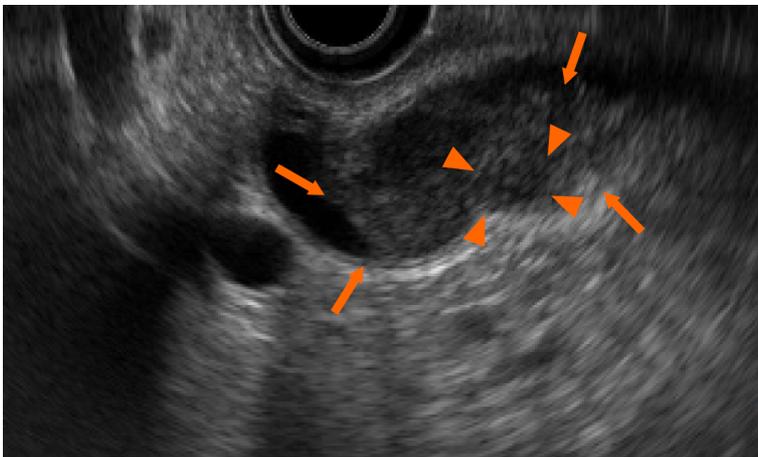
Endoscopic ultrasonography shows a heterogeneous echoic mass (arrows) with internal partially low echo (arrowheads). The mass extends into the lumen but does not infiltrate the serosa.
